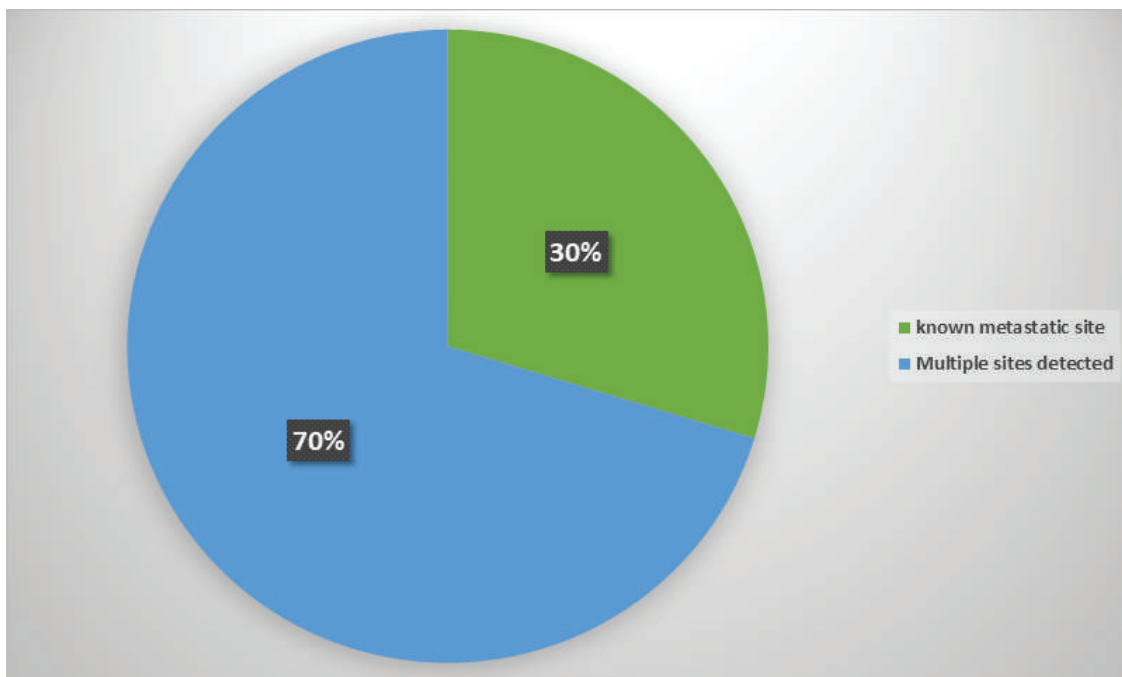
Known metastatic site and other multiple sites detected in PET-CT.
